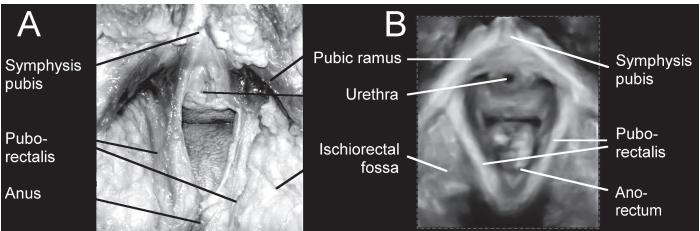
A. Intact puborectalis muscle in a fresh cadaver, dissected from caudally. The vulva, mons pubis, clitoris, perineal muscles and perineum to the anus, as well as peri- and postanal skin and the fibrofatty tissue of the ischiorectal fossa have been removed to allow access to the puborectalis muscle. B. The appearance of the puborectalis muscle in a rendered volume in the axial plane, using translabial 3D ultrasound.
